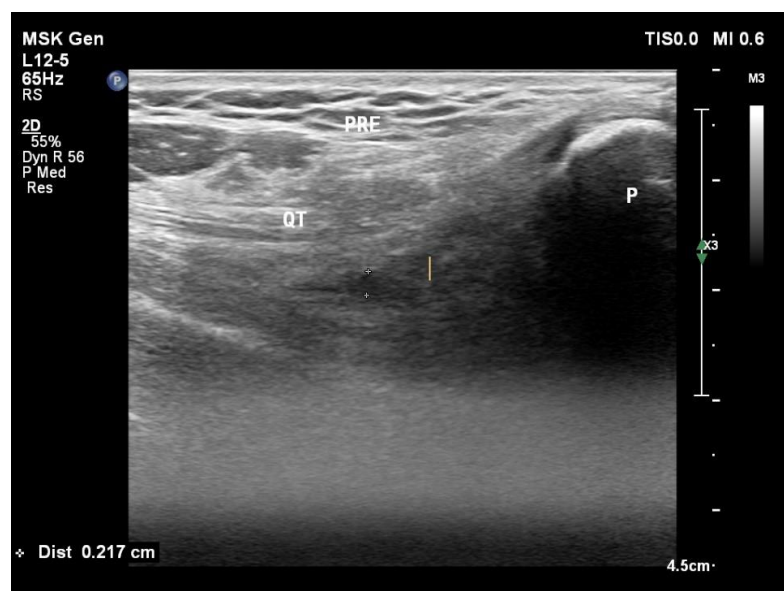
Pre injection suprapatellar pouch anterior-posterior dimension measurement using ultrasound
